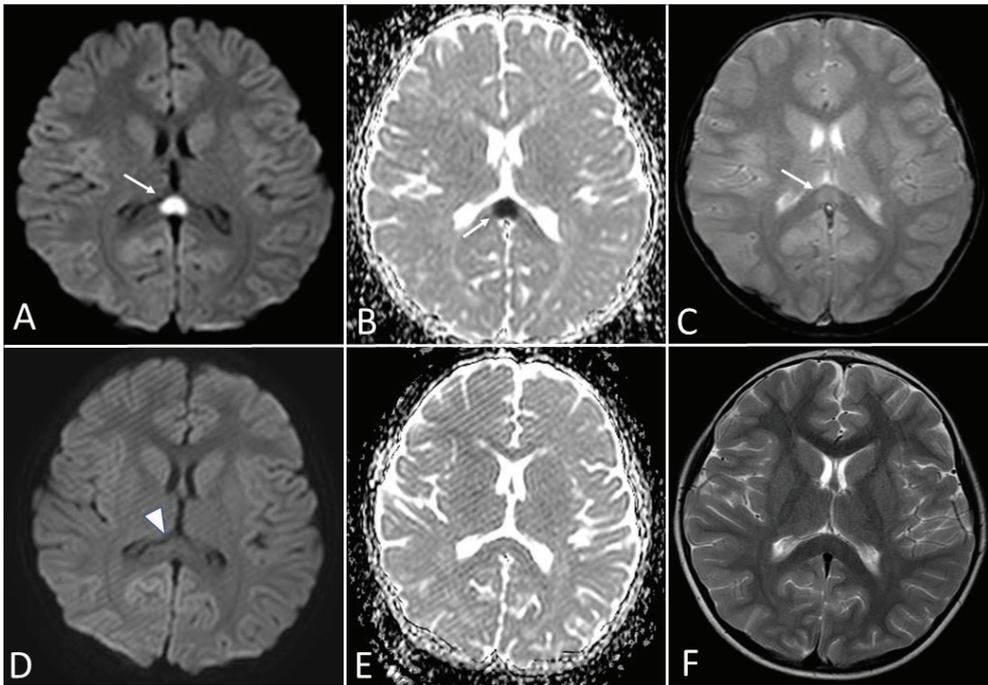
Cytotoxic splenic lesion. A) Increased signal intensity on axial plane Diffusion Weighted Image in the middle part of the splenium (arrow) B) ADC map shows low signal intensity on the same localization (arrow) C) T2 axial image show mildly hyperintensity (arrow) eight days control show normalization on DWI (arrow head) (D), ADC (E) and T2 (F) axial images
